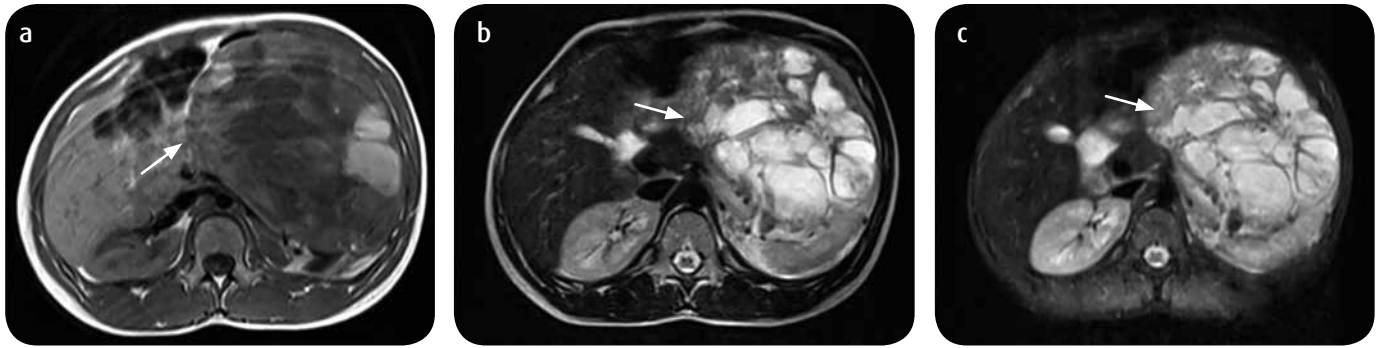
Left RCC in a 16-year-old patient. Stage III. MRI a) sequences with information T1 b) T2 and c) T2 with fat suppression. Large heterogeneous left renal tumor with areas of low signal with T1 information and high signal suggesting hemorrhages and intratumoral cystic lesions.
